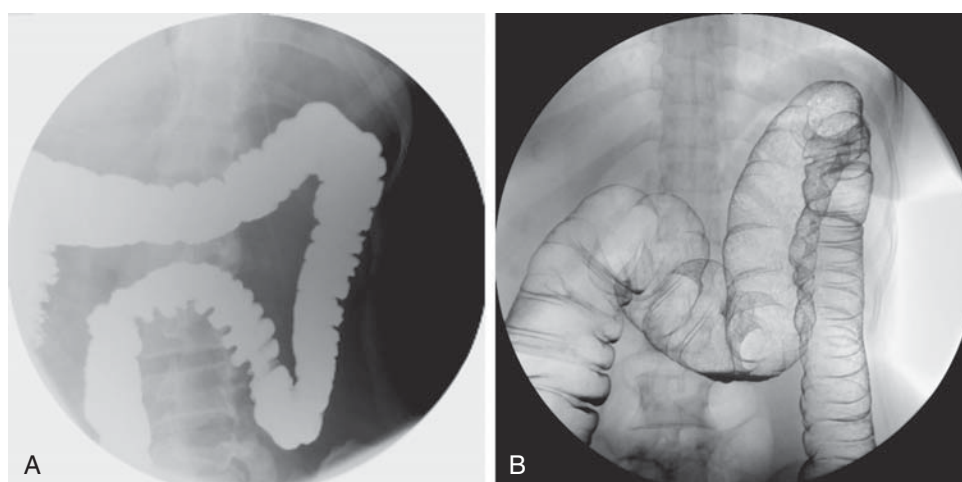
Spot radiograph of the mid-transverse colon obtained during single-contrast (A) and double-contrast (B) barium enema. The mucosal details are well seen on the double-contrast study.
